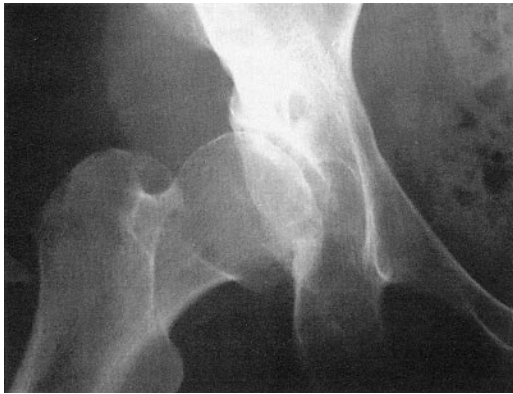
The anteroposterior radiograph of a 42-year-old woman shows the hip in abduction. The cartilage interval is narrowed at the lateral aspect of the joint. Acetabular redirection failed within 2 years.
